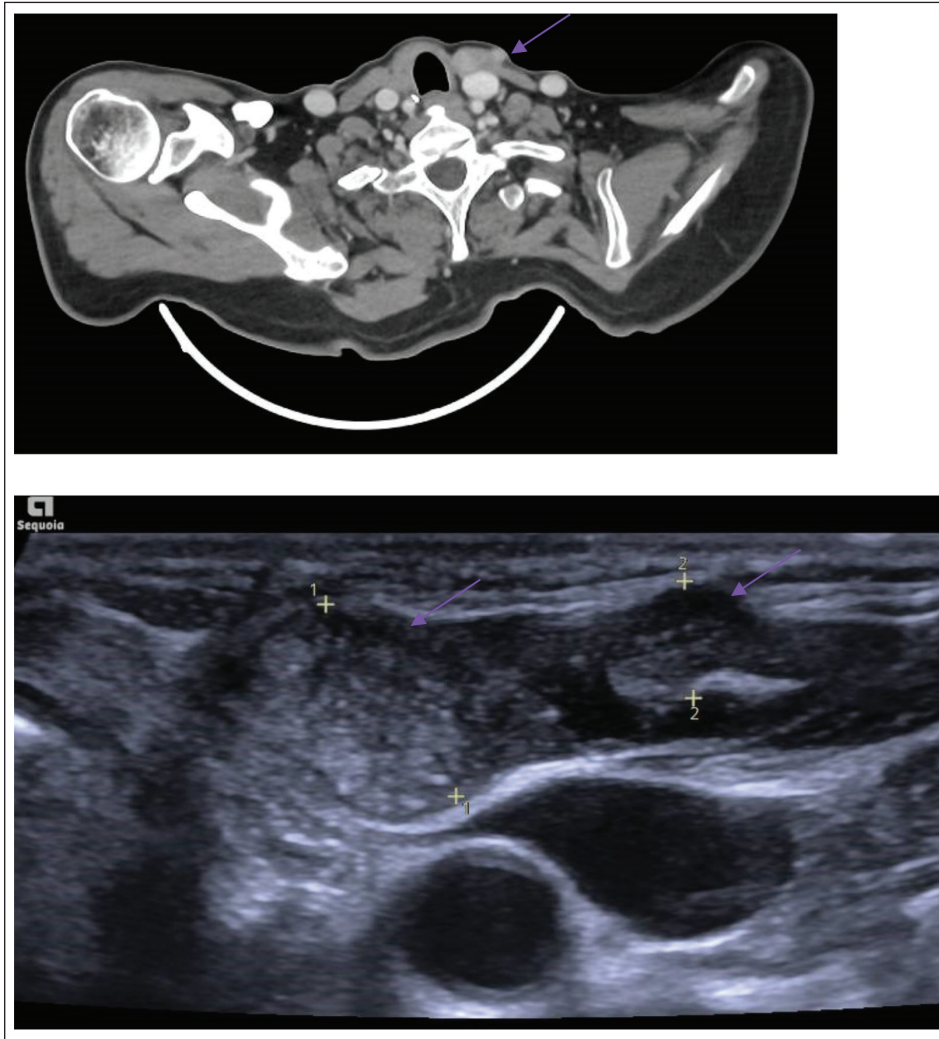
A - Axial CT demonstrating subcutaneous deposit of PTC with invasion of the left anterior strap muscles. B - US suggestive of two metastatic deposits within the dermis.
